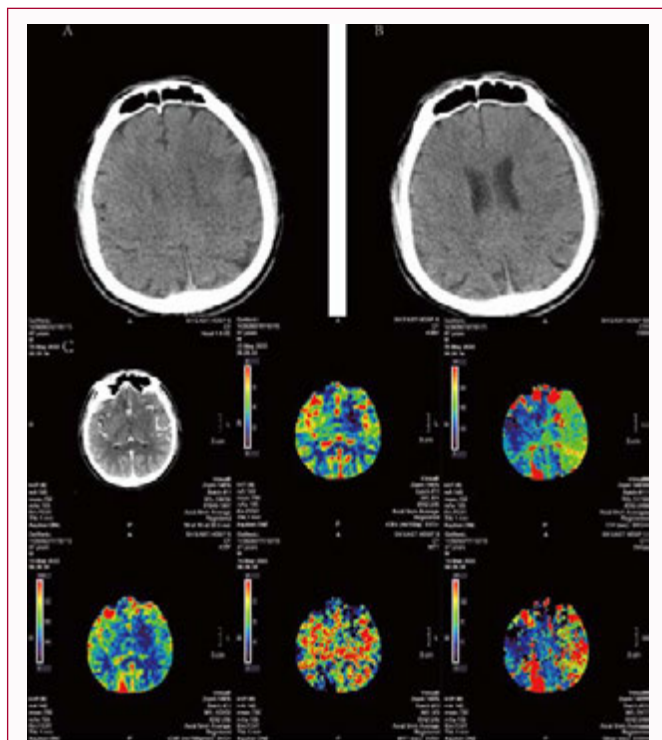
CT and CTP imaging before surgery. A) Non-enhanced Computed Tomography (CT) scan of the head (a) showing ischemic focus may exist in the left basal ganglia. B) The same with A. C) CT perfusion imaging showed abnormal blood flow and perfusion in the left basal ganglia.
